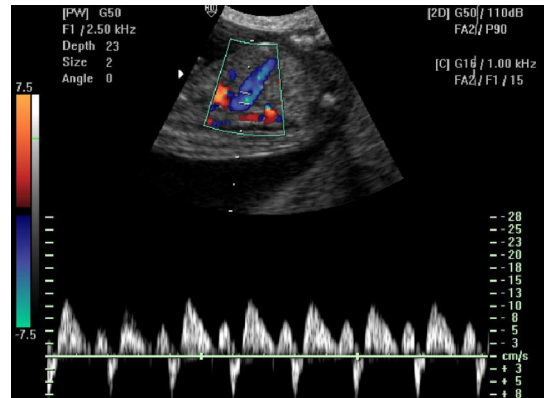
Doppler echocardiogram showed a presystolic reverse DV flow in a fetus of diabetic mother.
